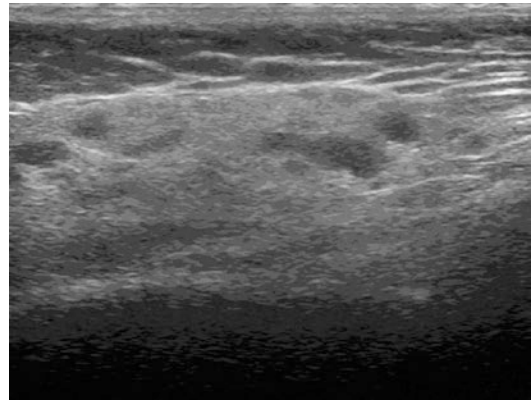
Ultrasound images of “moth-eaten” parotid gland with multiple hypoechoic areas consistent with salivary stasis (Image courtesy of M. Boyd Gillespie)
